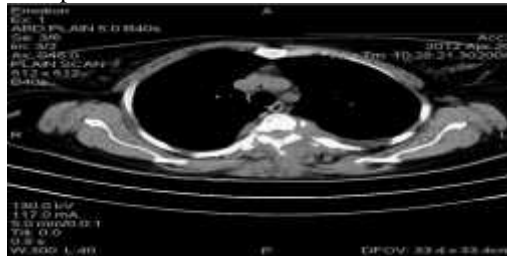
CT scan of Thoracic Spine Showing
